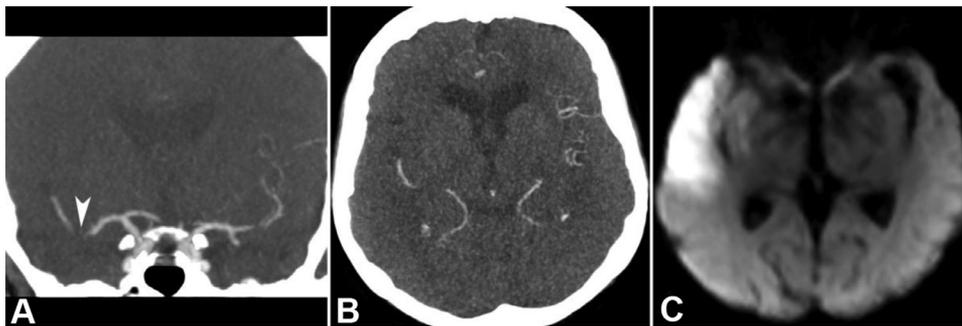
A case of poor collaterals and large final infarct volume. 64-year-old woman who presented with NIHSS of 5. (A) A coronal CTA demonstrates a distal right M1 occlusion (arrow). (B) An axial CTA demonstrates a poor collateral score in the right hemisphere (Tan score = 0). (C) Axial MRI DWI demonstrates a large stroke with a final infarct volume of 34.8 mL. Abbreviations: CTA, computed tomography angiography; DWI, diffusion weighted imaging; MRI, magnetic resonance imaging; NIHSS, National Institute of Health Stroke Scale.
